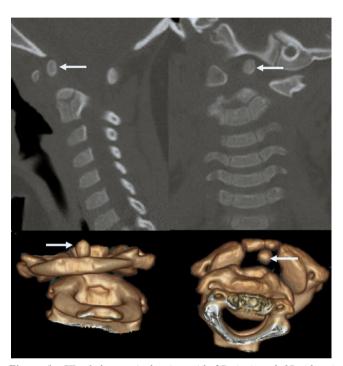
CT of the cervical spine with 2D (up) and 3D (down) reconstructions shows a dystopic os odontoideum (arrows). C1–C2 rotatory subluxation is also appreciable.
